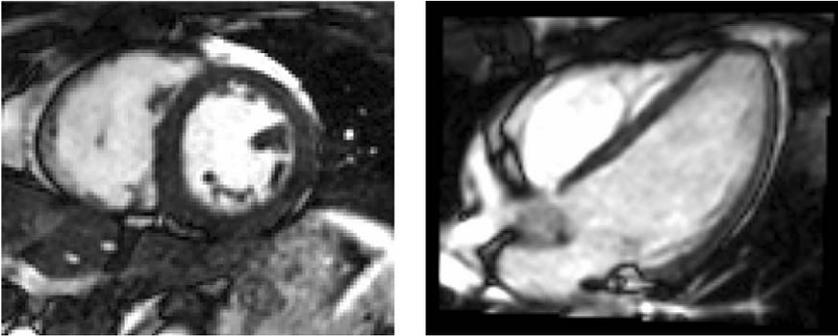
Short axis (*left*) and long axis (*right*) MRI CINE sequences. Videos available at <http://www.die.upm.es/im/videos>. Images courtesy of Hospital G. U. Gregorio Marañón (Madrid, Spain).
